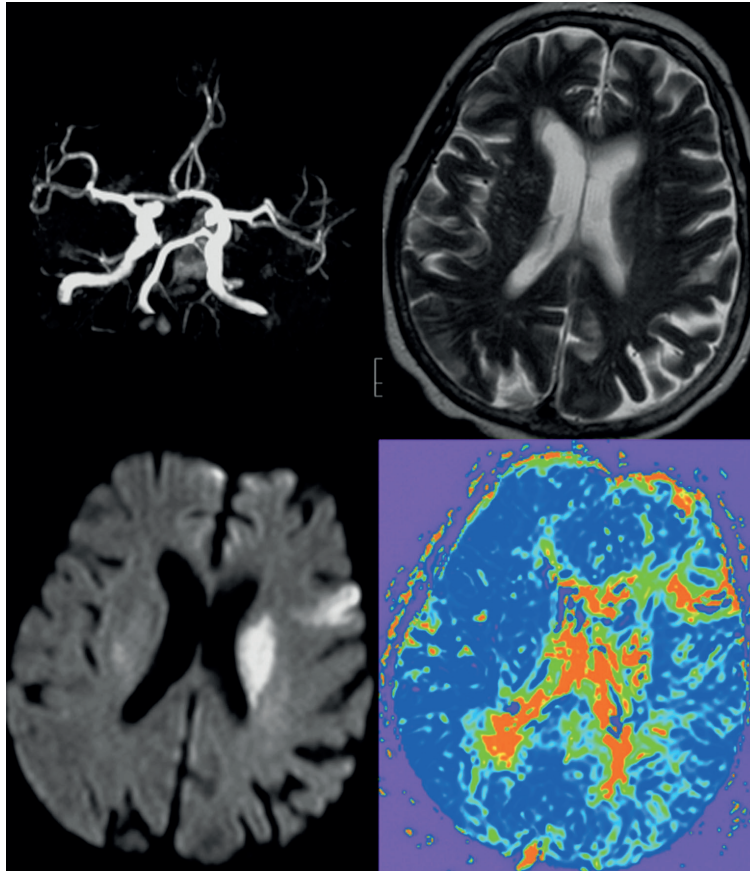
Four hours after acute onset of motor aphasia and right-sided hemiparesis MRA findings and T2-weighted images are normal (upper left and right), although MRA as part of a fast stroke MRI protocol does not allow the evaluation of the M3 and M4 segments reliably. A mild cortical hyperintensity at Broca's region and the corona radiata is visible on DWI. The perfusion disturbance is of about the same size as the DWI abnormality. As there is no mismatch and thus no "tissue at risk" (lower left and right), thrombolysis is not indicated.
